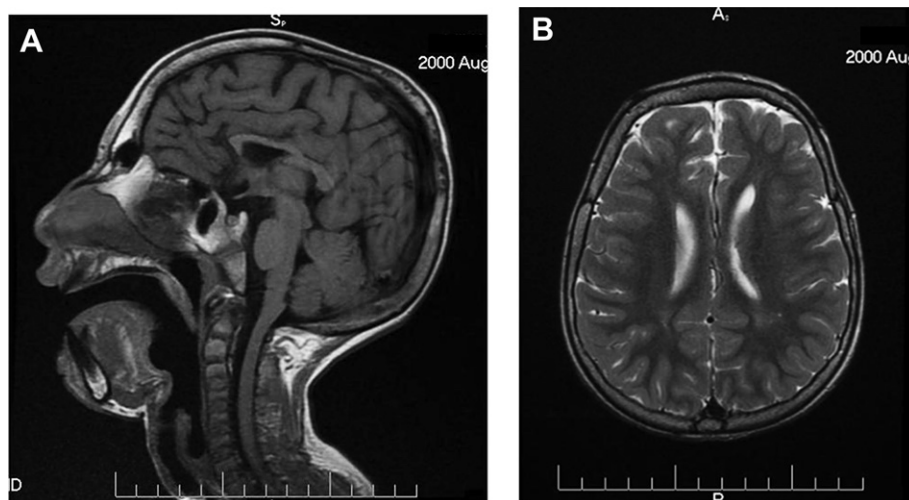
MRI images. A. midsagittal section. B. transversal section.
